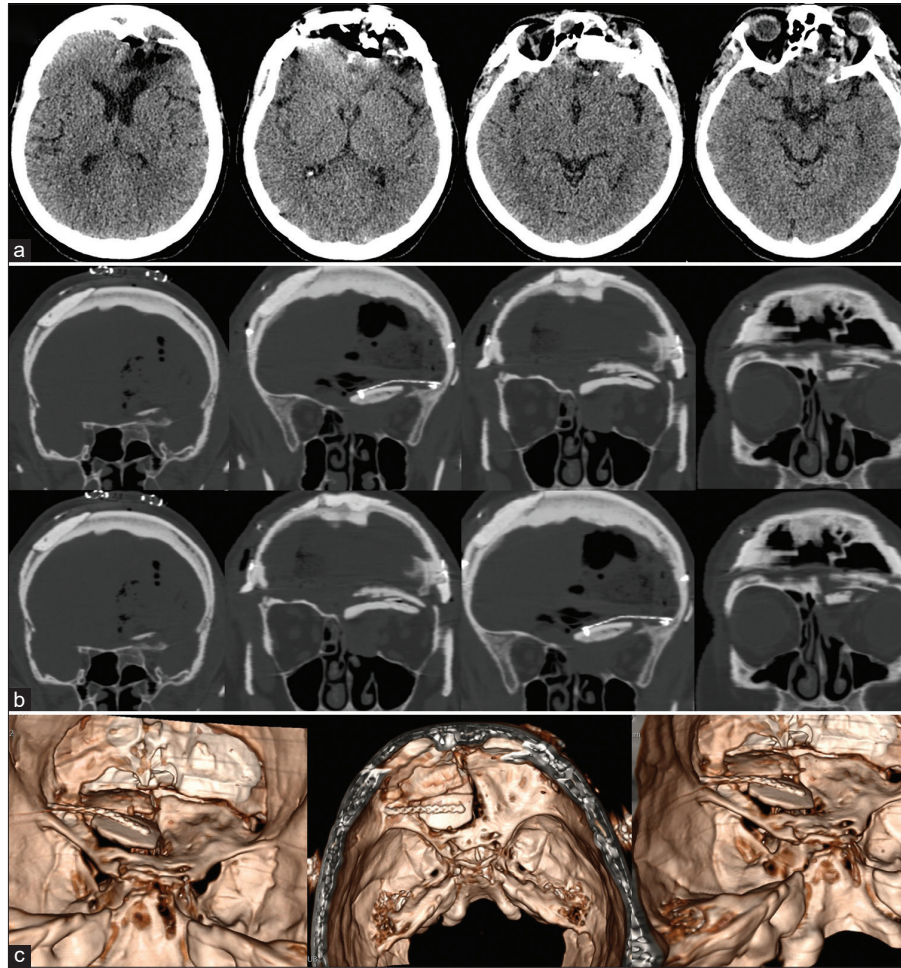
Postoperative axial head computed tomography scan images in series (a), with bone algorithm (b) and with 3D-reconstruction (c) showing a proper reconstruction of the left orbital roof and the medial orbital wall with split calvarial bone graft and bone defect reconstruction with methyl-methacrylate paste, obtaining good cosmetic and functional results.
